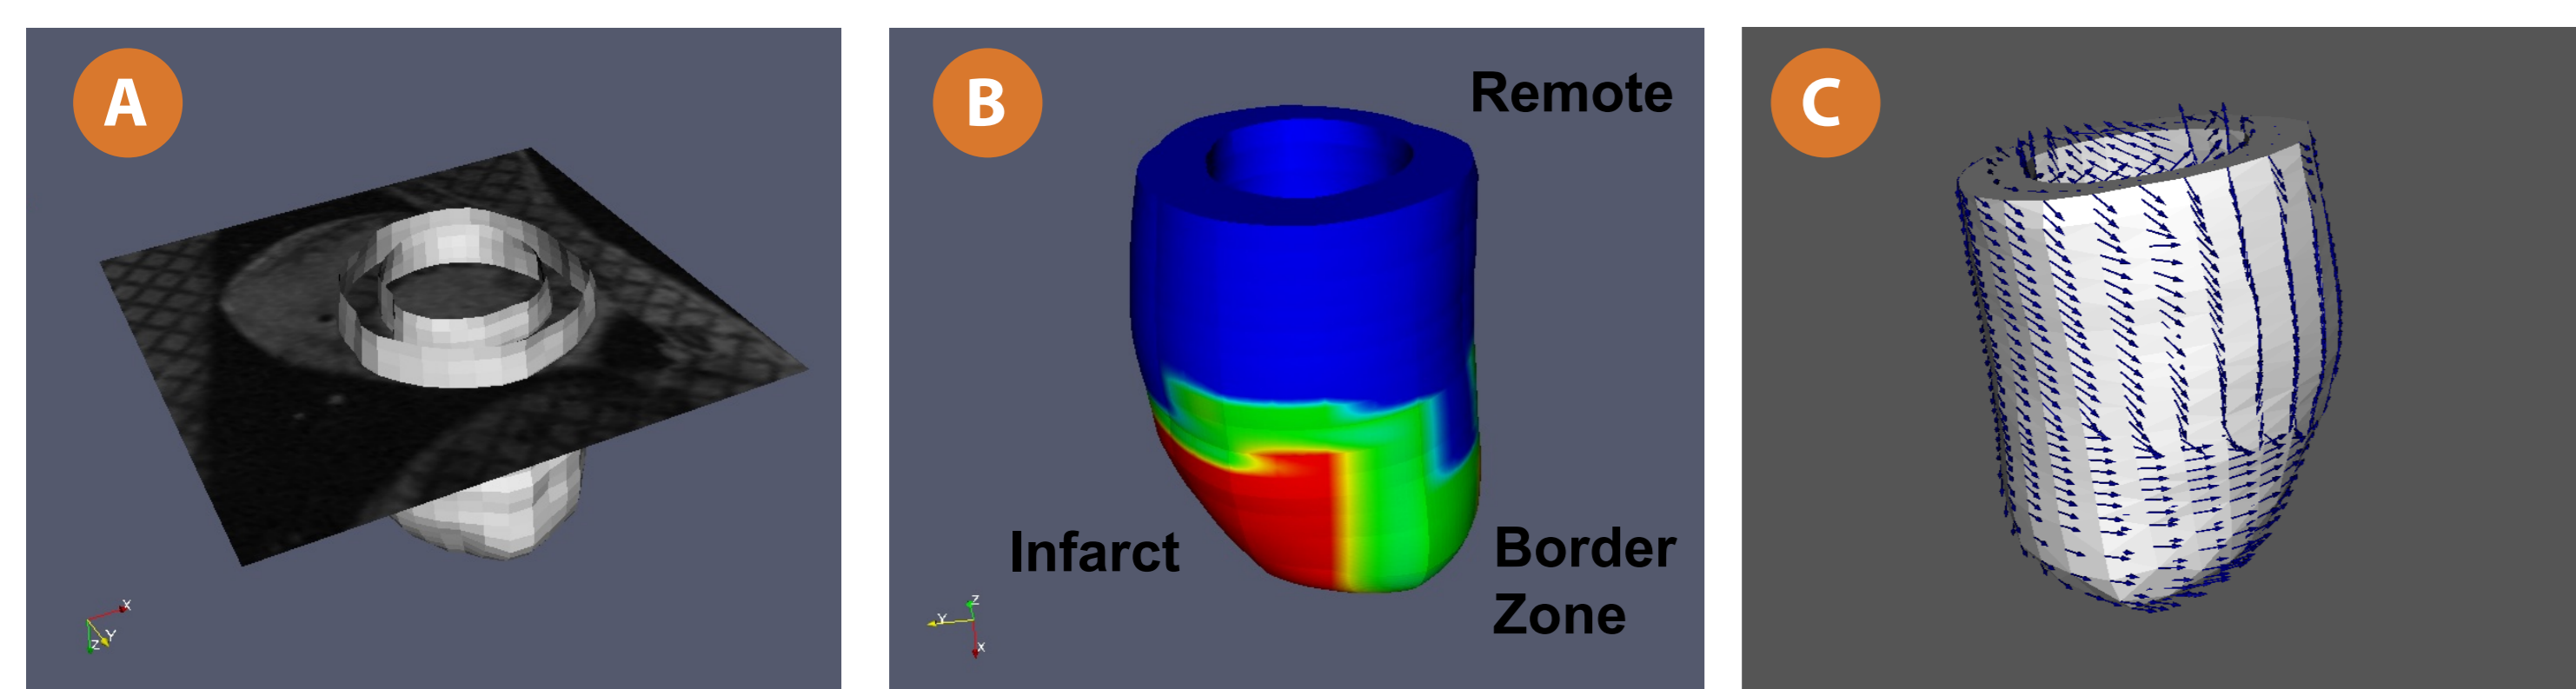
Depiction of contouring process from MRI images (A), along with final mesh (B) depicting zones of remote myocardium, infarct, and border zone. Fiber fields (C) are assigned at nodes from DT-MRI images and are set to circumferential orientation in the infarct.
